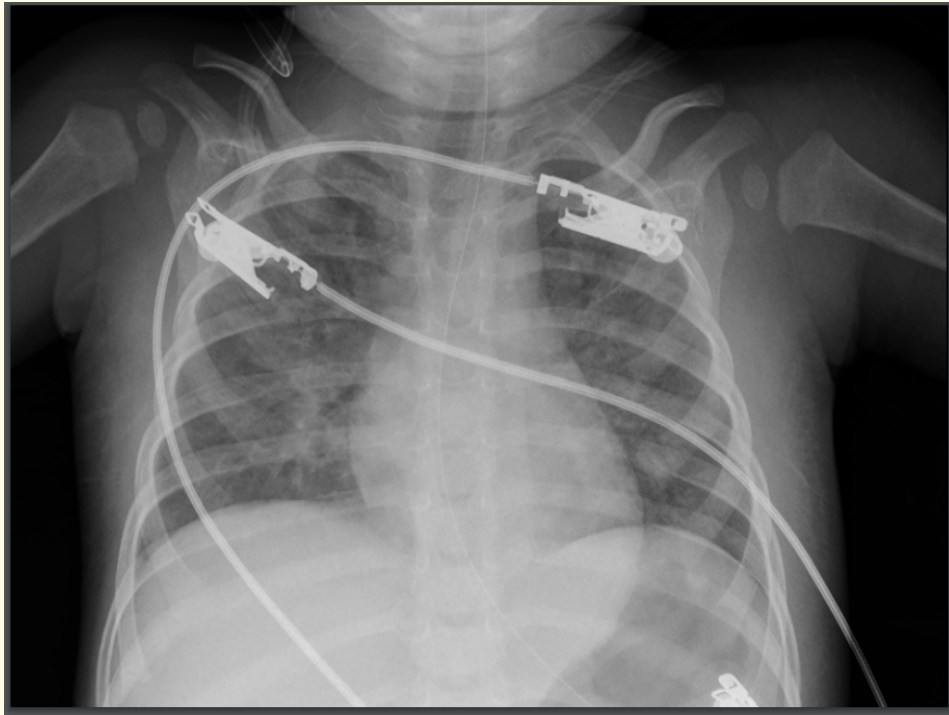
Chest x-ray showing diffuse bilateral infiltrates. Abdominal and chest ultrasound was also performed showing right lung infiltrates with pleural effusion of 30 cc, and left pleural effusion of 10 cc. It also showed abdominal space with ascitic fluid of 60cc, with increased intraluminal fluid in intestine loops, hepatomegaly with inflammatory changes and cholecystitis due to gallstones.
